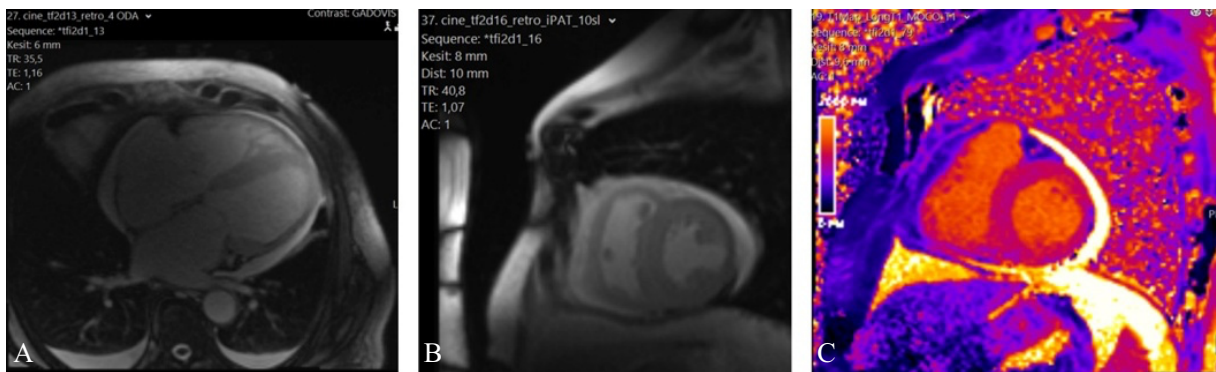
Cardiac magnetic resonance imaging findings consistent with cardiac AL amyloidosis. (A) Four-chamber steady-state free precession (SSFP) cine image demonstrating concentric left ventricular hypertrophy, biatrial enlargement, and a small pericardial effusion. Bilateral pleural effusions are also noted. (B) Short-axis SSFP cine view revealing symmetric myocardial thickening with global hypokinesia. (C) Native T1 mapping reveals diffusely prolonged myocardial T1 relaxation times, consistent with diffuse amyloid infiltration and interstitial expansion, in the absence of myocardial edema.
